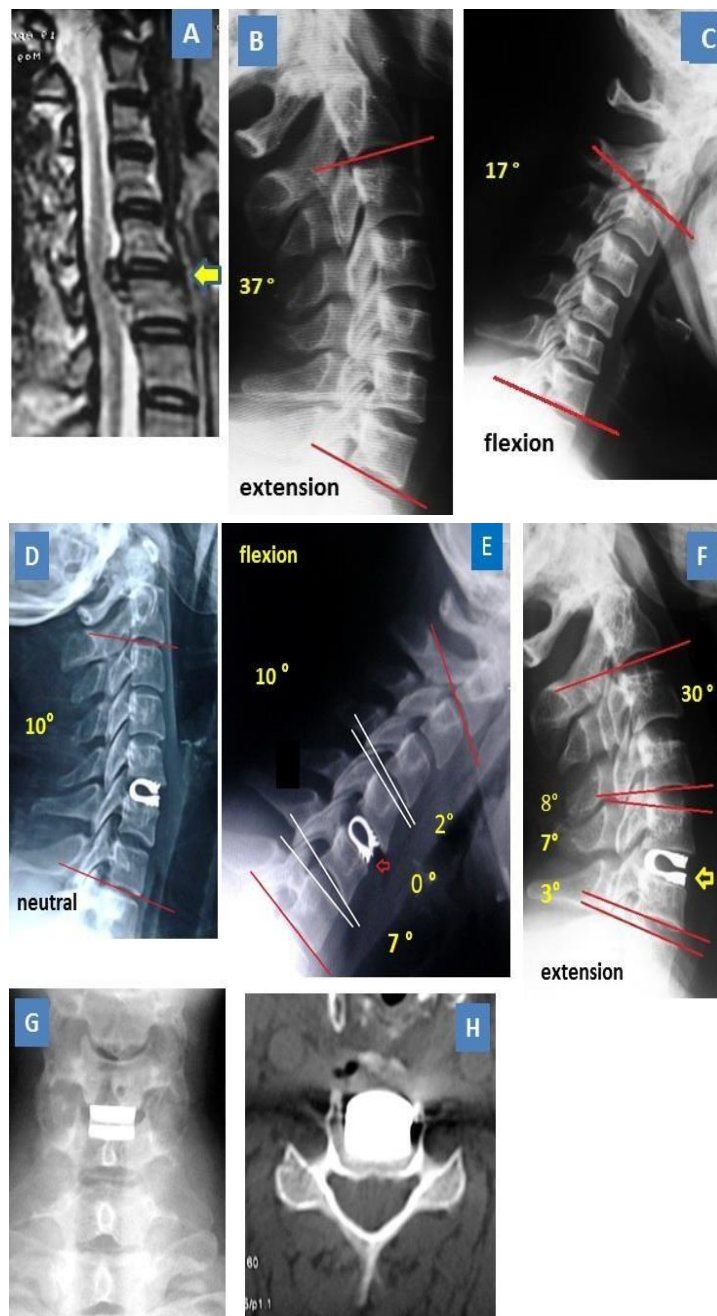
39 ys old lady with C5-6 DDD; (A) preop. MRI, (B&C): preop. Dynamic views: 46° GROM, (D) final lateral neutral view: good position of DCI & 10° overall lordosis, (E&F): final dynamic views: maintained 7° ROM at implanted level, good GROM & no hypermobility of adjacent levels, (G&H): good position of DCI.
